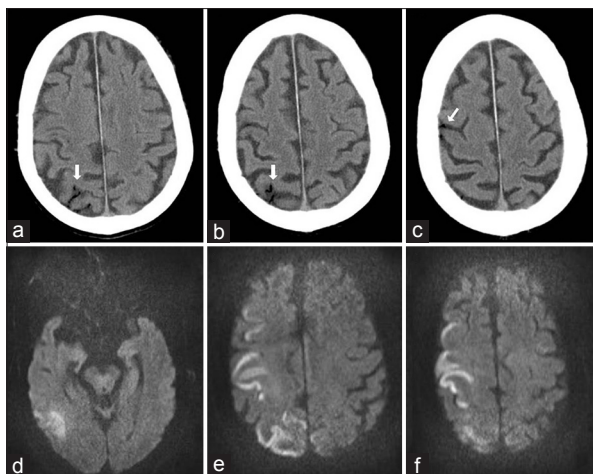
(a-c) Noncontrast computed tomography, axial sequences, showing sulcal air in the precentral and central sulci of right frontal cortex and intraparietal sulci of right cerebral hemisphere. (d-f) Brain magnetic resonance imaging axial diffusion-weighted sequences demonstrating gyriform restricted diffusion corresponding to sulcal air
